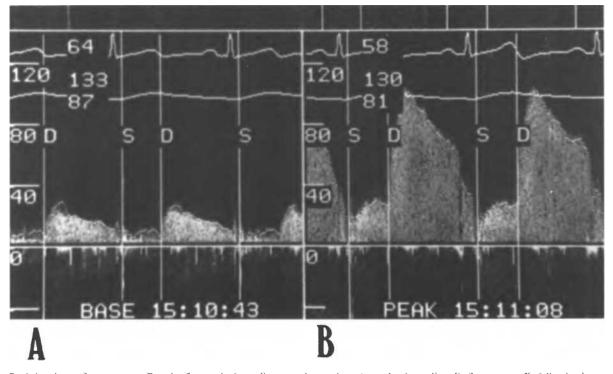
Real-time image from coronary Doppler flow probe in cardiac transplant patient: A: predominant diastolic flow, at rest; B: following hyperemic stimulus with adenosine. CFR = Hyperemic flow + rest flow
